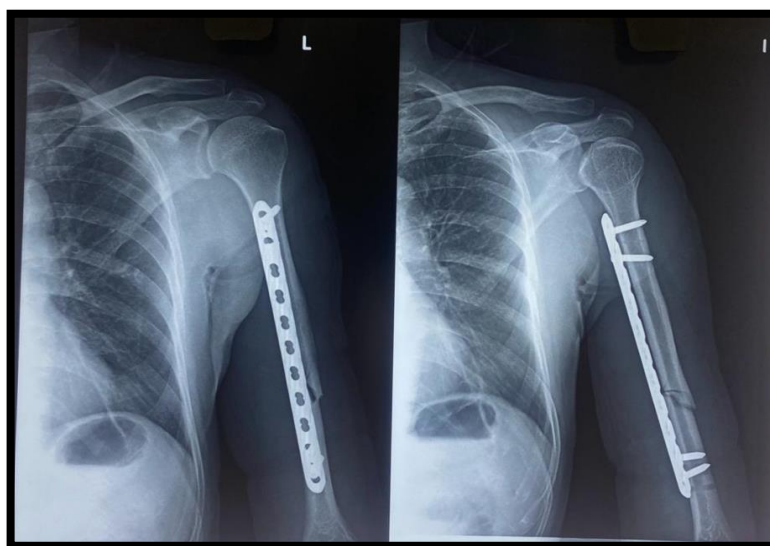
Immediate post op Xray
